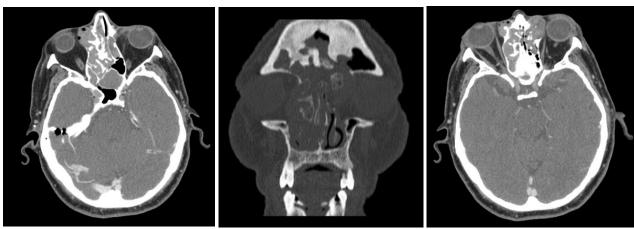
Computed tomography of the craniofacial complex shows soft tissue density occupation in both nasal fossae, predominantly on the right, maxillary sinus, anterior and posterior ethmoid, frontal and bilateral sphenoid with erosion of the lamina papyracea and invasion of the anterior skull base
